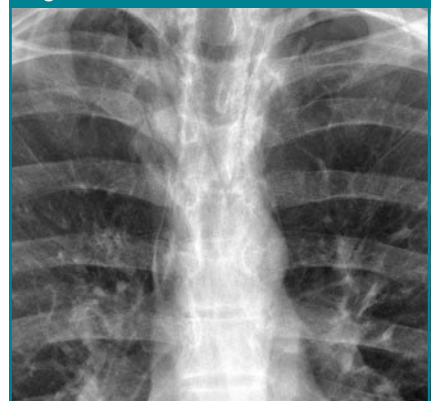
Magnified chest radiograph shows pneumomediastinum.
